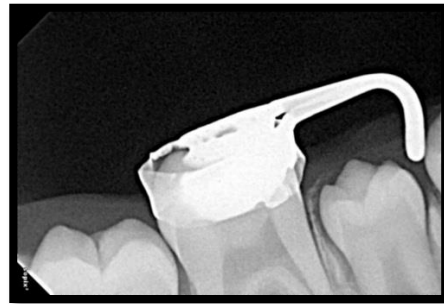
Radiograph revealing the Depth
